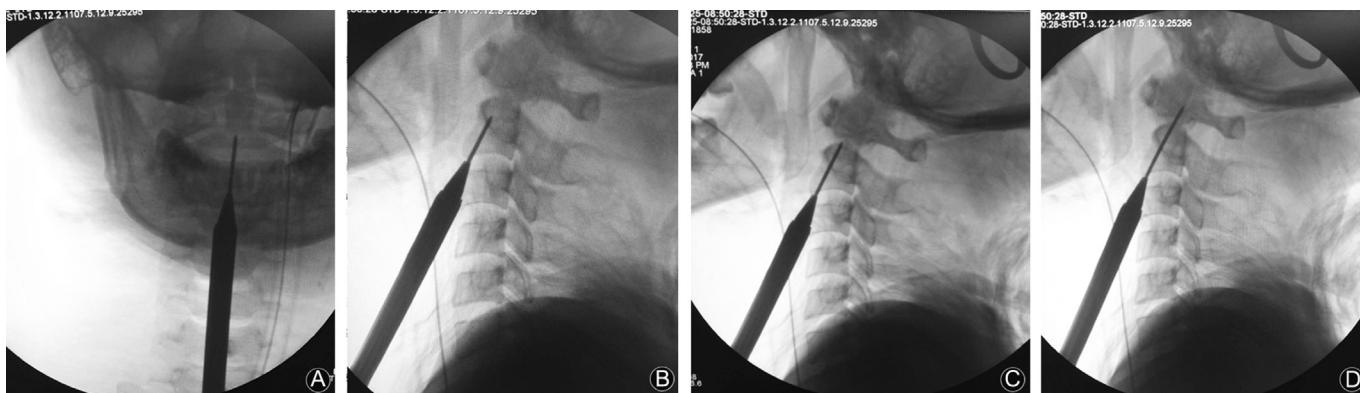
The intraoperative anteroposterior (A) and lateral (B, C) radiographs showed the guide wire was in good position. The intraoperative lateral (D) radiograph showed the odontoid process was displaced to the front of the wire.
